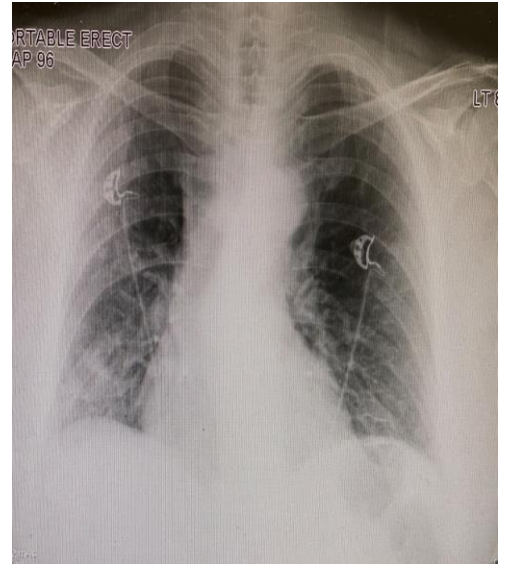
AP portable chest radiograph
